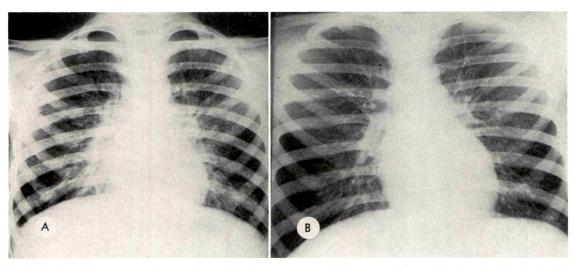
(A) Chest roentgenogram made when the patient was  $5\frac{1}{2}$  years old and was first seen with a bronchopneumonia. Cultures grew Friedländer's bacillus. Response to treatment was slow, but a follow-up at 9 years of age (B) shows very little pulmonary abnormality other than emphysema. Throat cultures, however, persistently grew Pseudomonas.
